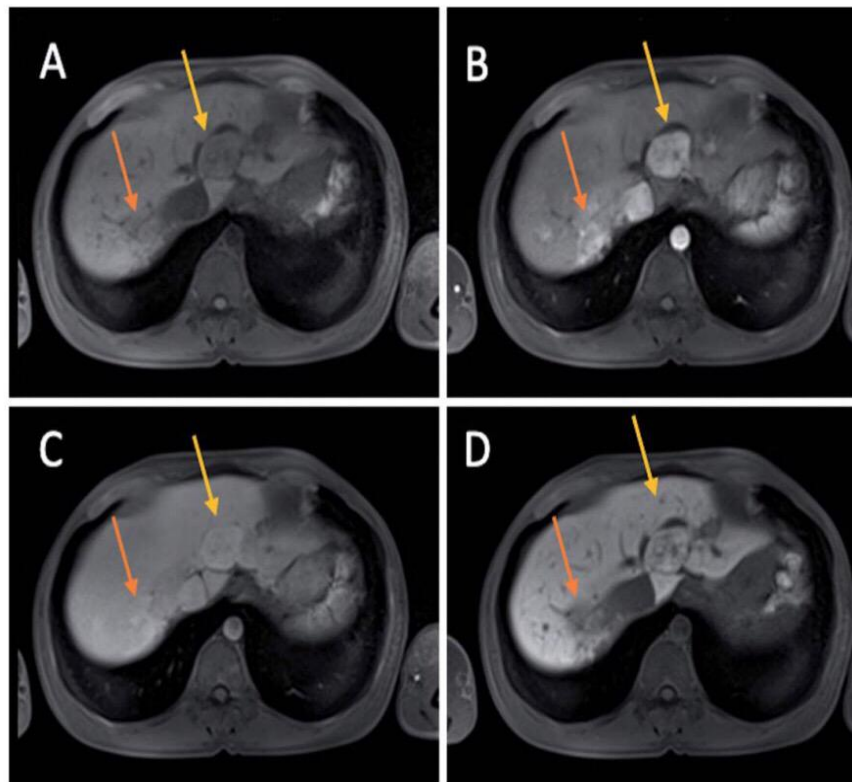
Same patient as in Figure 6 and 7. MRI of the FNH (3,5 cm) lesion in segment 4 (yellow arrows). Hemangioma in the right liver lobe (orange arrows; 14 cm). Sequences are fat saturated. T1 weighted sequences without (A) and with (B-D) contrast agent. A: Hypointense lesion in native T1 weighted sequence (yellow arrow). B: Intense enhancement of the lesion in the late arterial phase (yellow arrow). C: Isointense enhancement of the lesion to liver on portal venous phase relative to the liver parenchyma (yellow arrow). D: FNH lesion fades toward background liver intensity on the delayed hepatobiliary phase and show a homogeneous appearance with enhancement remaining (yellow arrow); hypointense enhancement if compared to the liver parenchyma.
